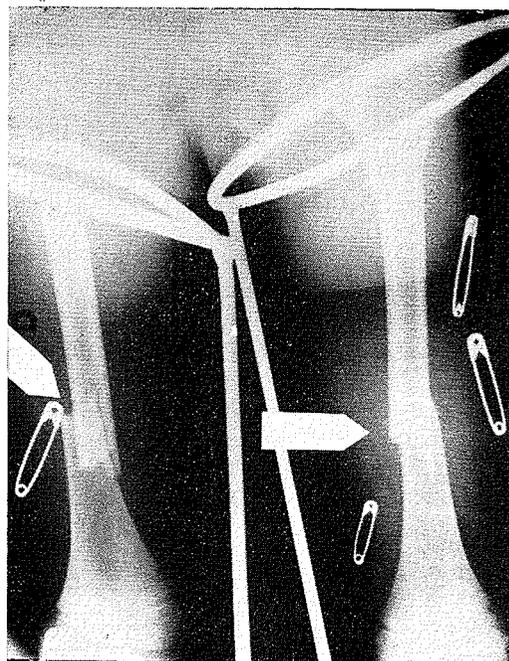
Case 0131: X-ray showing fractures of both femurs
